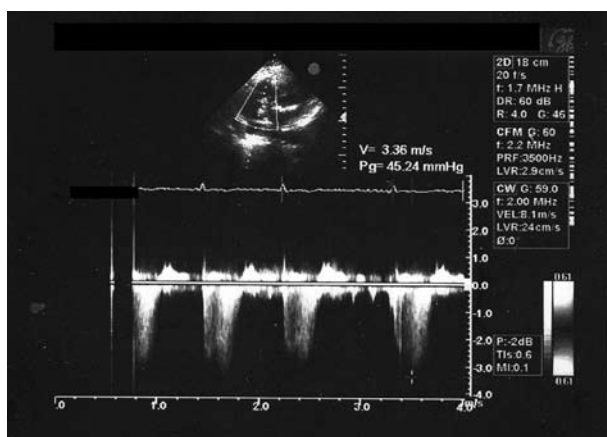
Transthoracic echocardiogram revealing tricuspid regurgitation and elevated systolic pulmonary arterial pressure (55 mm Hg).
